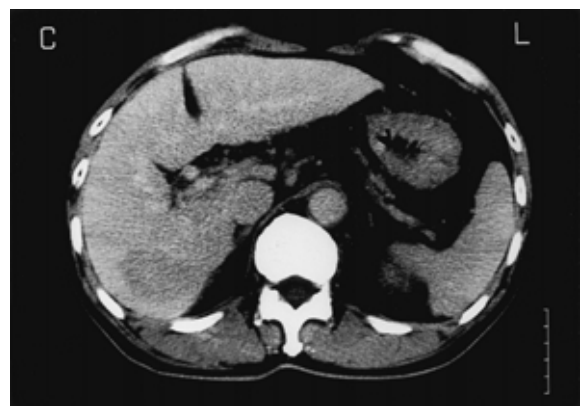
Case 4. A CT image delayed by seven minutes
